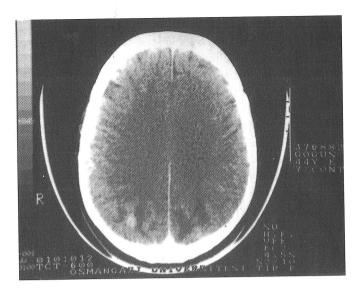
Cerebral CT scan showed bilateral occipital brain metastases of malignant mesothelioma.
